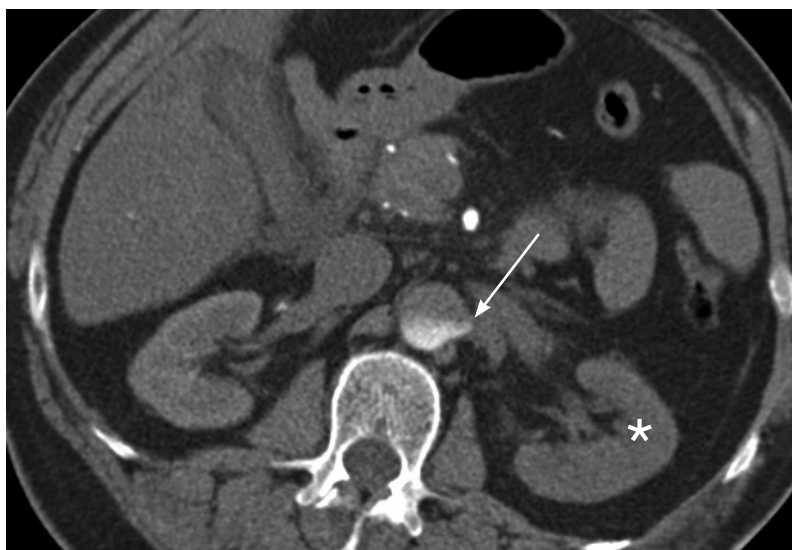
Axial section of a computed tomography angiogram at the level of the renal arteries. The dissection flap extends into the left renal artery (arrow) resulting in reduced enhancement of the left kidney (asterisk) compared to the right kidney.
